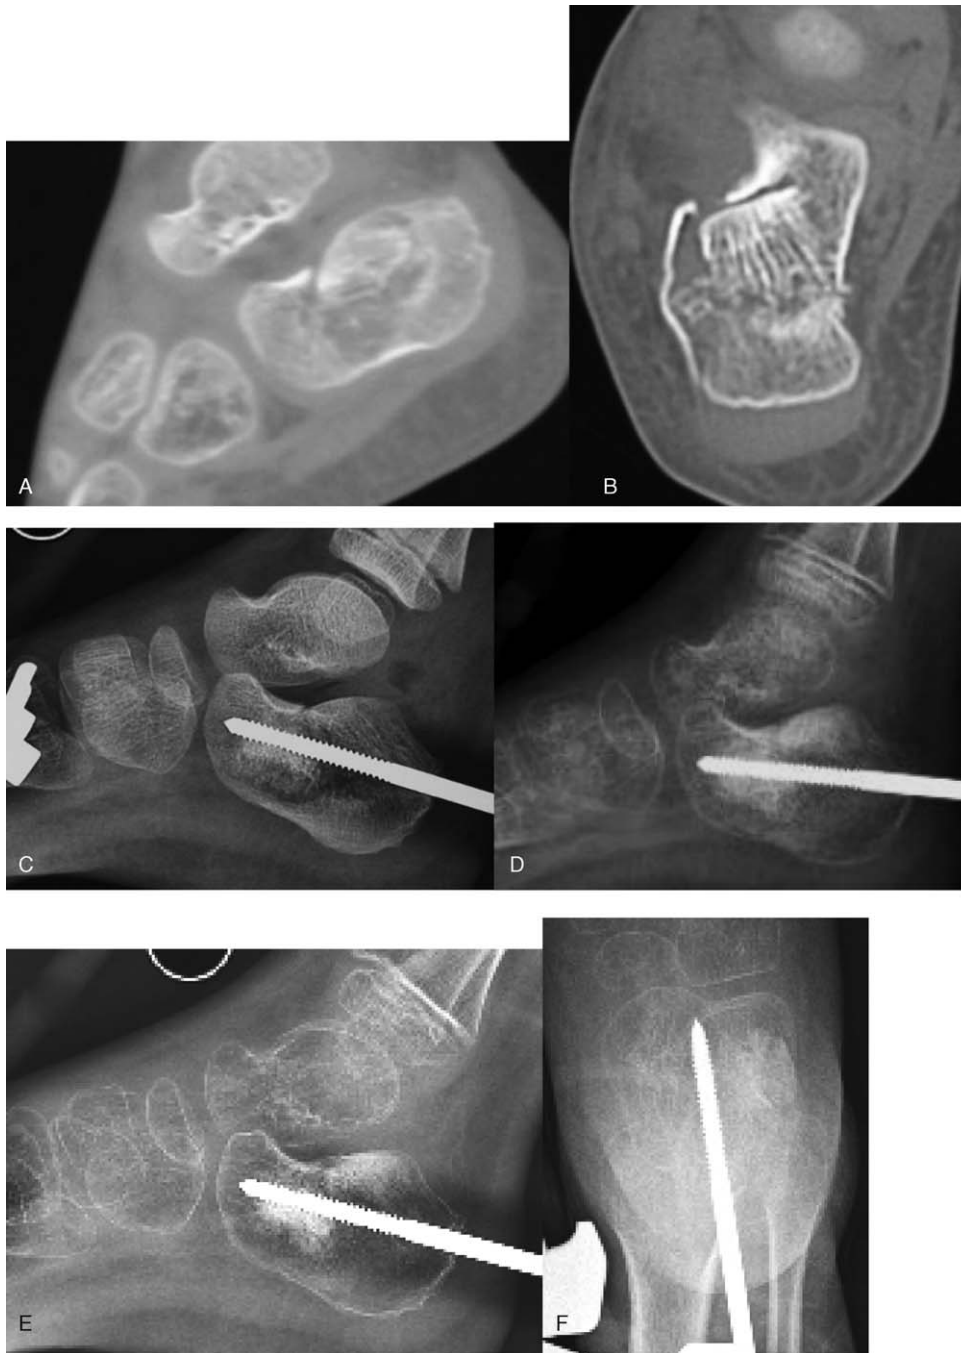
A 9-year-old boy of calcaneal fracture. (A) Sagittal plane of CT scan of calcaneal fracture before surgery. (B) Cross-section of CT scan of calcaneal fracture before surgery. (C) Lateral X-ray of calcaneum after surgery. (D) Lateral X-ray of calcaneum at first month follow-up. (E) Lateral X-ray of calcaneum at second month follow-up. (F) Axial view of calcaneum at second month follow-up.
